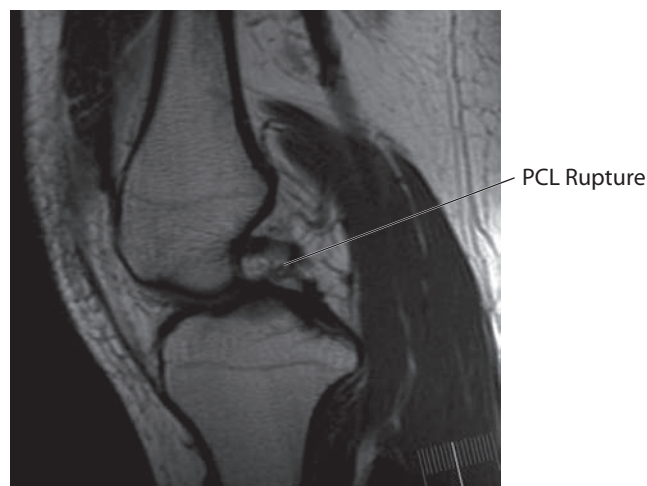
Magnetic resonance imaging of a ruptured posterior cruciate ligament.
